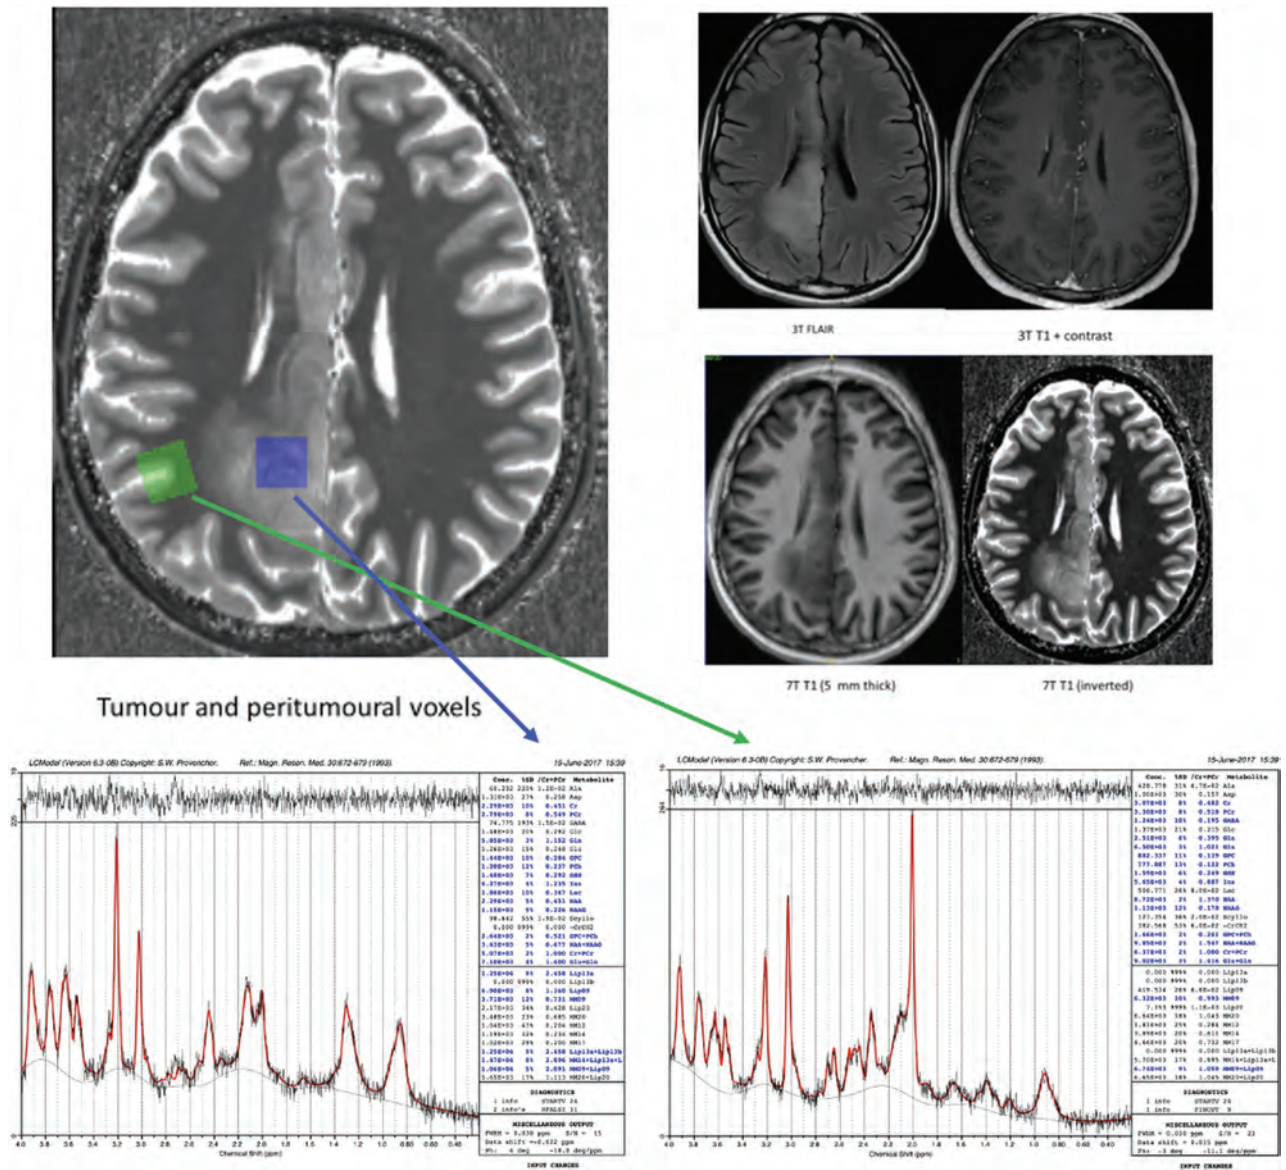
3T/7T MR imaging data, 7T SVS data, and LCMoDels from a patient with diffuse glioma are presented (TR/TE for the 7T SVS data = 8500/6 ms), with tumor data on the left (blue arrow) and peritumoural data on the right (green arrow) for each patient. Inspection of the MRS metabolic profiles shows that the peritumoural region has a relatively normal profile except for a highly elevated Glu concentration compared with both Gln and Cr. This is in contrast to the tumoral region, where there is a complete reversal of this profile with Gln and Cho being elevated compared with Glu, NAA, and Cr. These data provide further evidence of the dysregulation of the Glu-Gln shuffle, serving as a source of seizures in patients with gliomas. This material was obtained with permission and in collaboration with Andrew Neal and Bradford A. Moffatt at the Melbourne Brain Centre Imaging Unit (MBCIU), the University of Melbourne node of the Australian National Imaging Facility.
